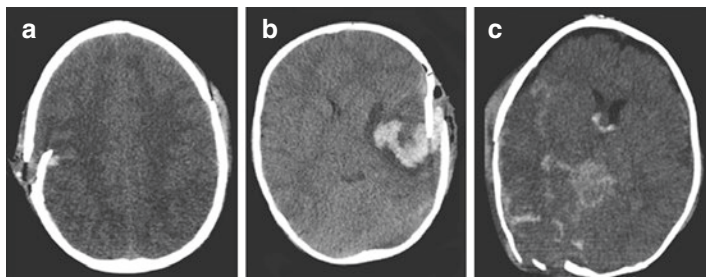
CT scan showing (a) depressed skull fracture; (b) depressed fracture and associated traumatic intracerebral hematoma and; (c) depressed fracture and associated traumatic SAH and contusions
